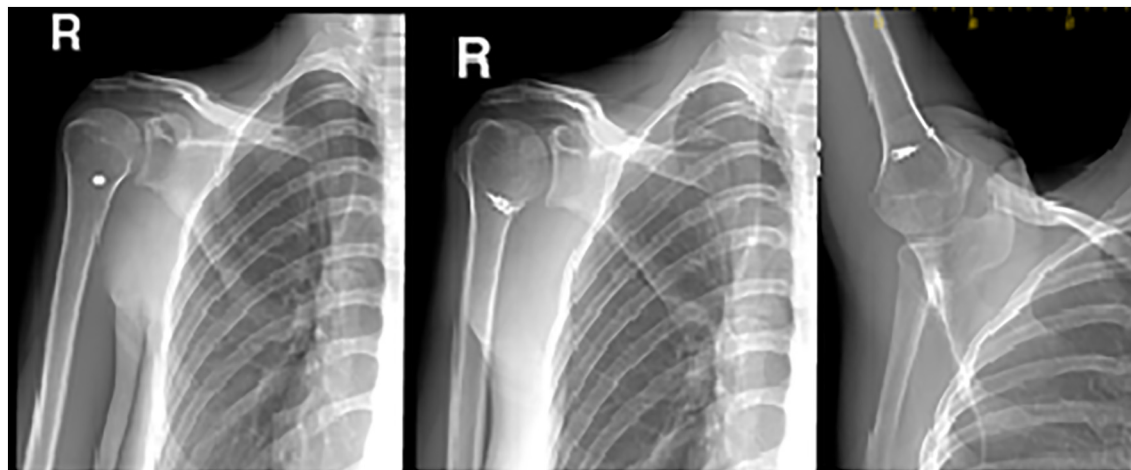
Follow up X-rays of the right shoulder showing construct and anchor stability on multiple ROM positions.
